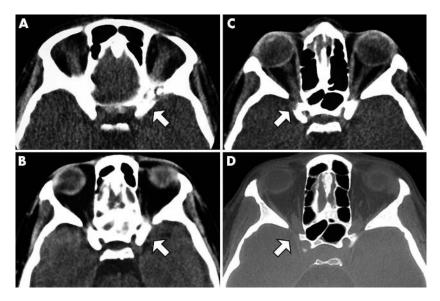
Axial CT scan images taken during the period July 2001 to October 2003, with arrows highlighting the area of interest in each image. (A) July 2001, showing lytic areas within the bones around the left anterior clinoid process. (B) October 2001, the left lytic areas have been replaced by sclerosis. (C) May 2002, showing lytic areas within the bones around the right anterior clinoid process. (D) October 2003, the right eye changes have resolved.
